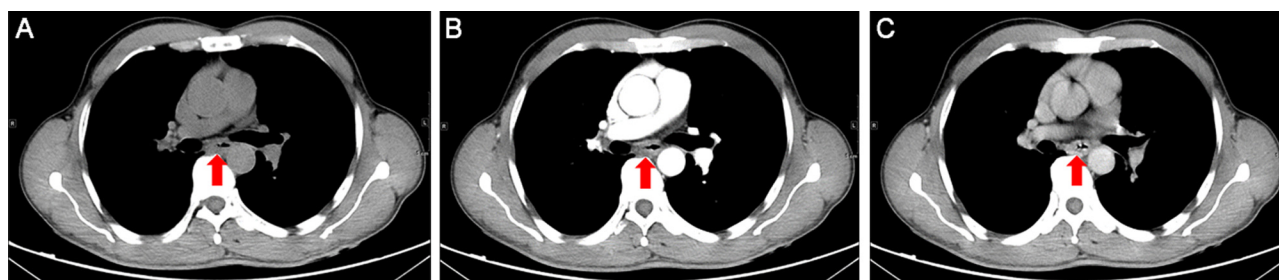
The initial thoracic CT indicated that the middle thickening esophageal wall was markedly enhanced. Plain scan (A); arterial phase (B); venous phase (C).
